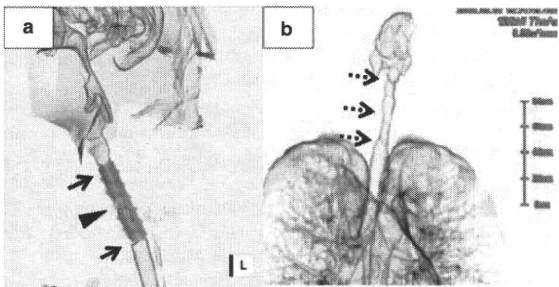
CT scan air-emphasized images of trachea before and after operation. (a) Case no. 2 before operation. A cannula was inserted in the region of STC (black arrows); black triangle indicates the stomal orifice. (b) Case no. 2 after operation. Although the region of STC remains, the inner space of the trachea (black dotted arrows) is maintained without the cannula.
